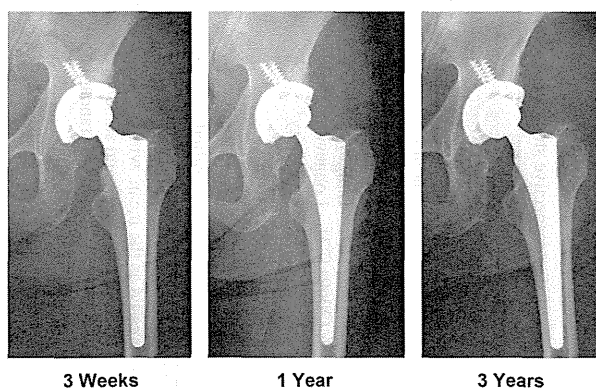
Radiographs of a representative case (Case 66). Radiographs obtained 3 weeks, 1 year, and 3 years after surgery, showing no findings related to implant migration or periprosthetic osteolysis.
